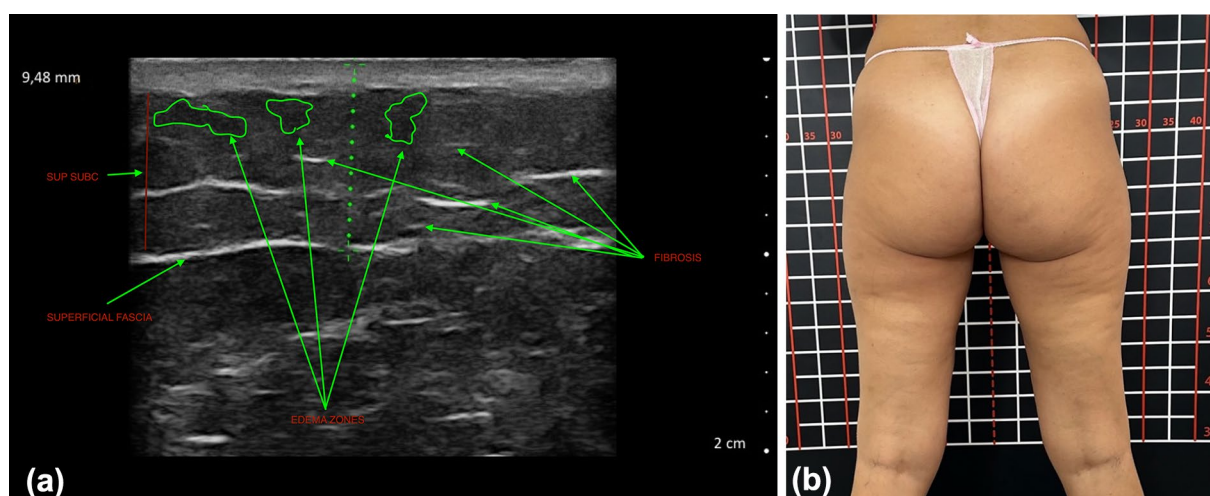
Patient with a stage 3A phenotype. a Ultrasound image showing a superficial fat layer of low thickness (<7 mm) with homogeneous echotexture and minimal fibrotic septa. b The clinical image showing mild dimpling without nodules, indicative of predominant edema and mild fibrosis. *SUP. SUBC* superficial subcutaneous tissue, *SUBC* subcutaneous tissue, *DEC* dermo-epidermal complex
